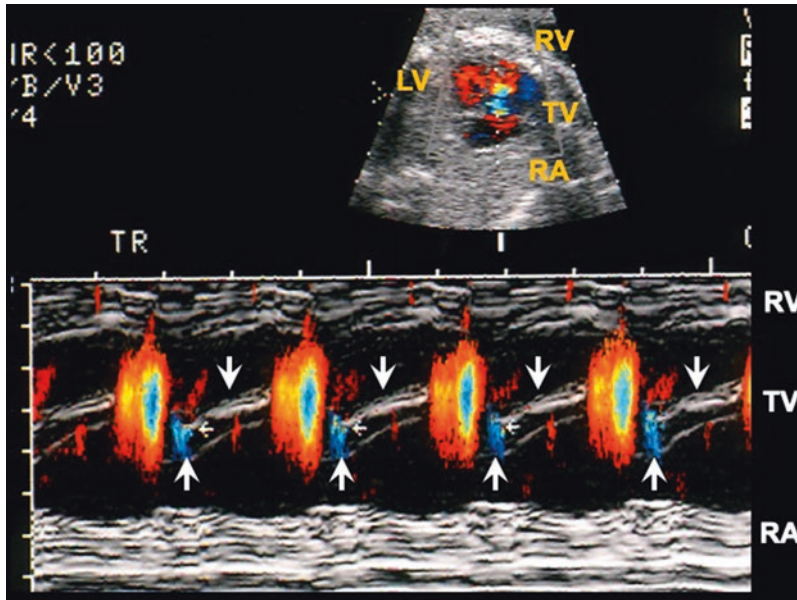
Color M-mode echocardiogram of the fetal heart showing fetal tricuspid regurgitation. Top: Color Doppler image of the apical four-chamber view with the M-line cursor passing through the right ventricle (RV) and right atrium (RA). LV left ventricle, RV right ventricle. Bottom: color M-mode tracing. The atrioventricular flow
